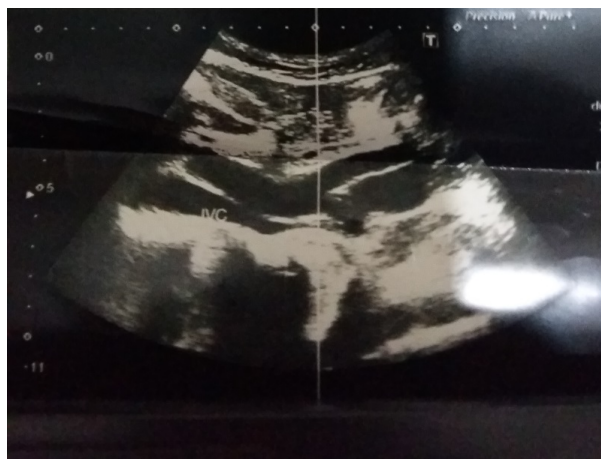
Ultrasonographic image of Inferior vena cava including proximal parts of common iliac veins
